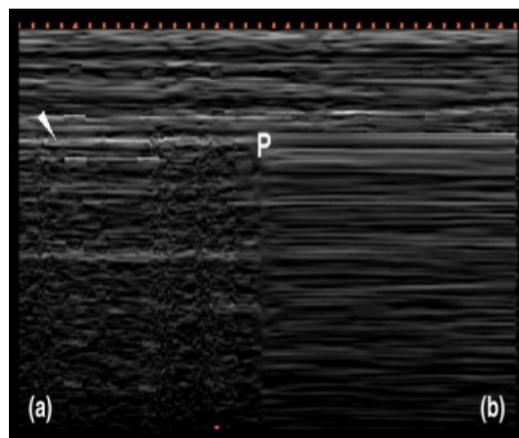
“Lung point sign” M-mode ultrasound (a) aerated lung showing seashore sign. (b) pneumothorax (stratosphere sign), (P) indicates point of transition. (courtesy of Husain LF *et al.* J Emerg Trauma Shock. 2012).
